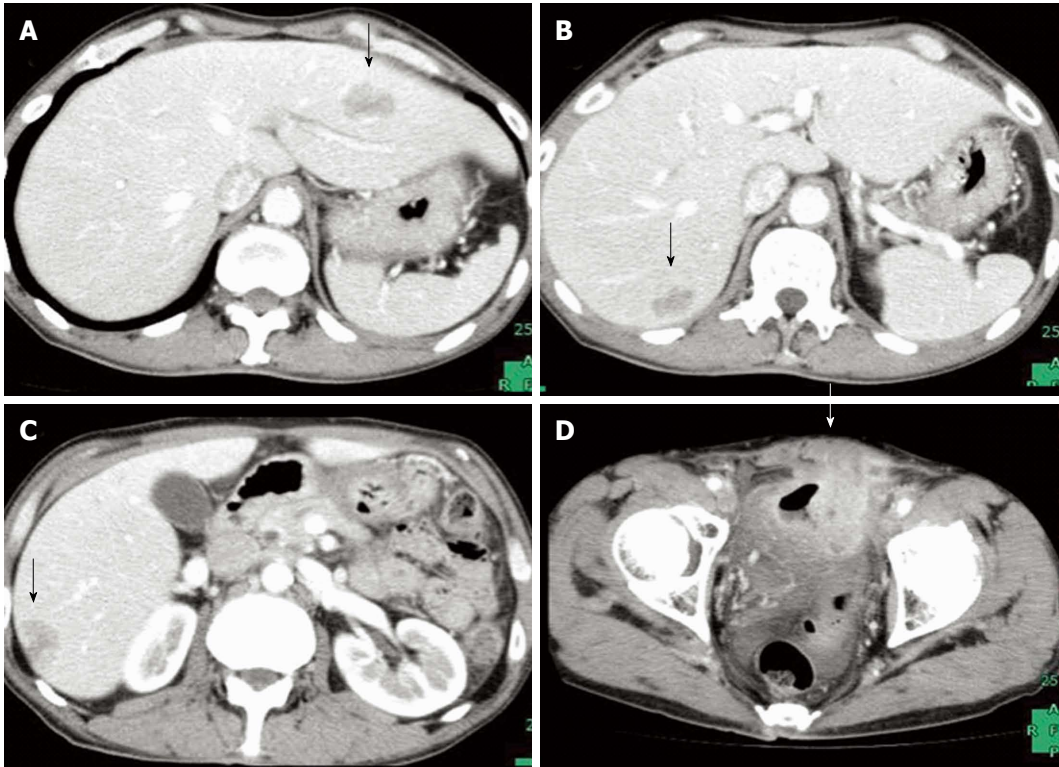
Computed tomography before treatment showed multiple liver metastases (arrows) and a primary upper rectal tumor that had invaded the urinary bladder. A, B: Multiple liver metastases; C, D: A primary upper rectal tumor.
